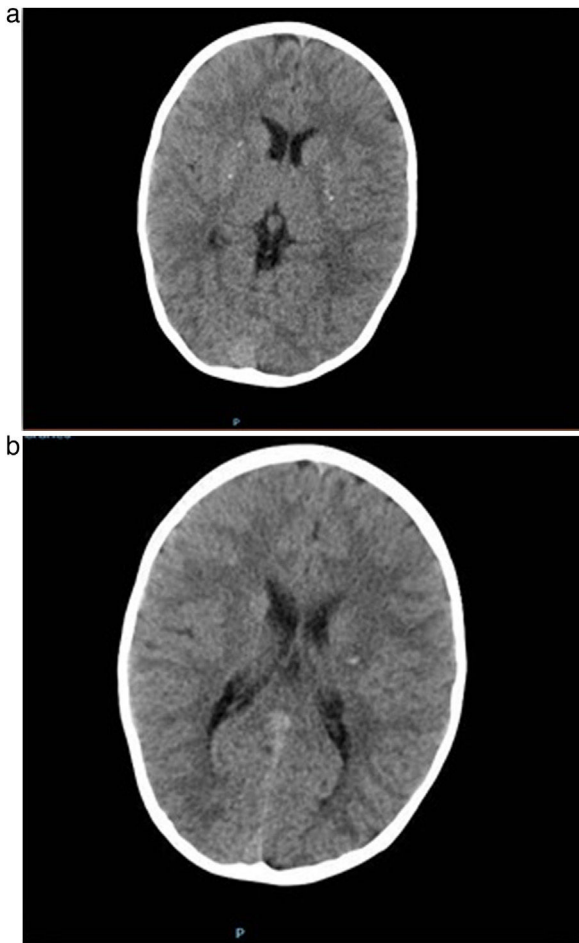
(a) Axial head CT image showing punctiform calcifications in the basal ganglia of both brain hemispheres. (b) Axial head CT image showing a hypodense lesion in the left corona radiata, containing calcifications.
